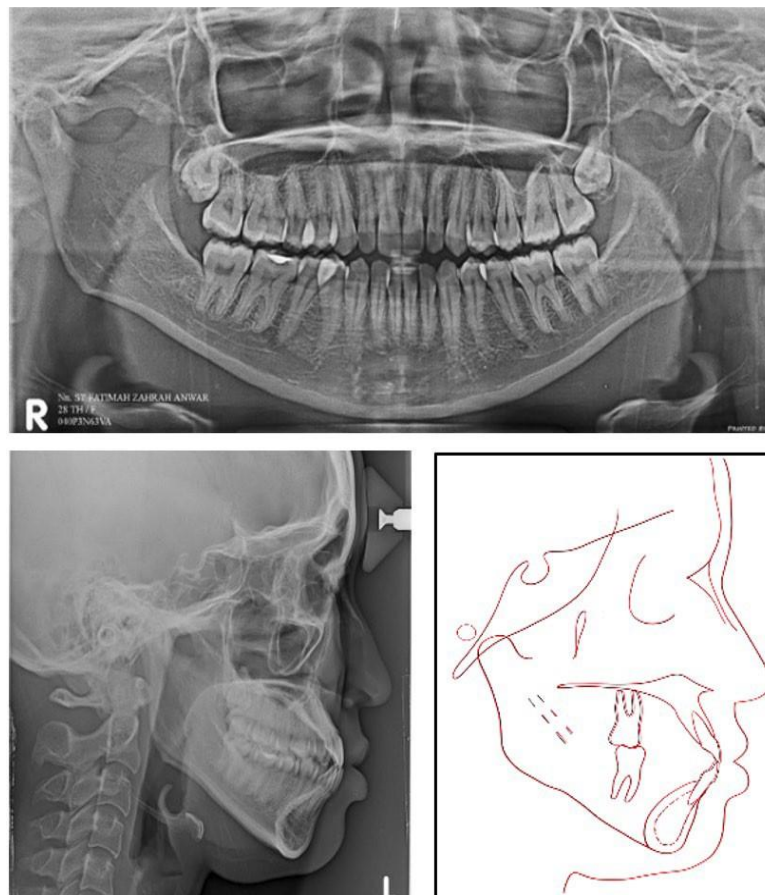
Pre-treatment panoramic and cephalometric radiograph
